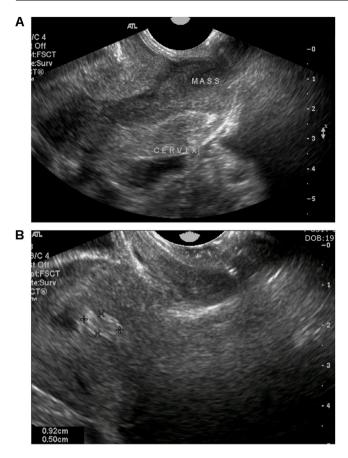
Transvaginal sonography of the patient. (A) Protruding cervical mass to the upper vagina. (B) $0.9 \text{ cm} \times 0.5 \text{ cm}$ sized endometrial mass.
